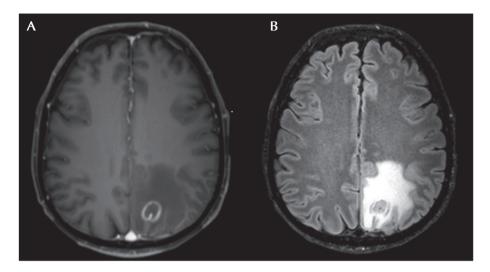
Case 2. Brain MRI of the patient with CNS toxoplasmosis. (A) Axial T1 with gadolinium showing the eccentric target sign. (B) Axial T2 FLAIR demonstrates the lesion with prominent surrounding vasogenic edema.
